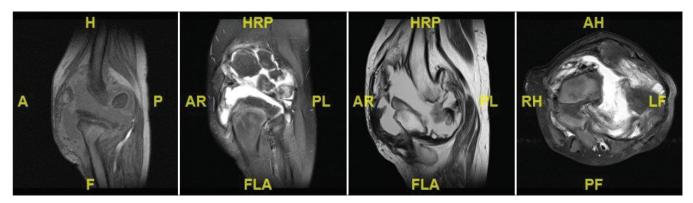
Magnetic resonance imaging of both knees showing significant soft-tissue swelling and significant joint effusion, as well as bony destruction involving femoral condyle and tibial condyle extending to the lower femoral metaphysis and upper tibial metaphysis with subluxation with significant loose bodies in the joint space.
